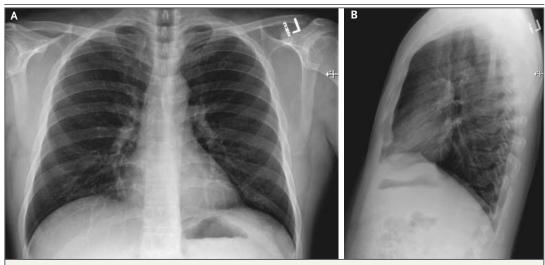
Posteroanterior and Lateral Chest Radiographs, January 19, 2020 (Illness Day 4). No thoracic abnormalities were noted.
